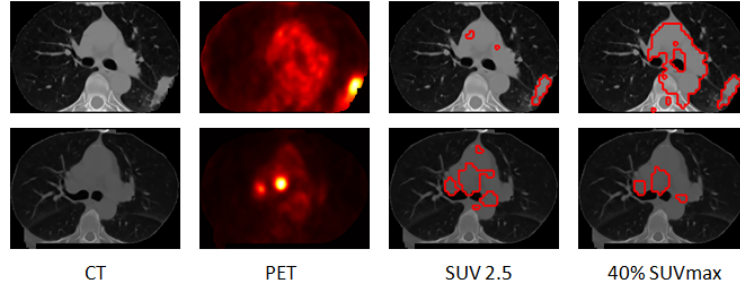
Two examples showing the thresholding outputs using the standard SUV threshold of 2.5 or 40% of the maximum SUV. Axial slices (CT and PET) after preprocessing (see Section 2.3) are shown. The red contours drawn on the CT images indicate the detected lesions using the respective thresholding techniques. Both techniques result in some false positives in both cases.
